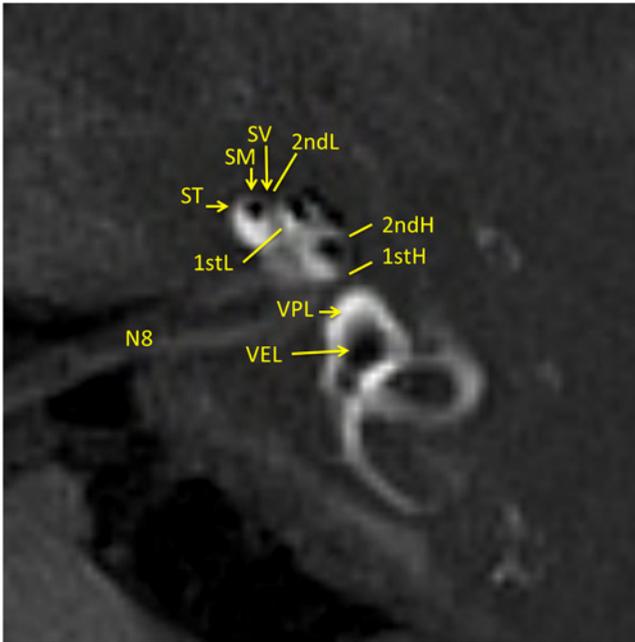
Separate visualization of endolymphatic and perilymphatic spaces and bone in human using 3D real IR TSE on 3 T MRI after intratympanic administration of Gd-DTPA. Images were obtained 24 h after transtympanic injection of 50 mM Gd-DTPA at 3T using a 32 channel head coil. N8: 8th cranial Nerve; SM: Scala Media; ST: Scala Tympani; SV: Scalavestibuli; VEL: Vestibular Endolymph; VPL: Vestibular Perilymph; 1stL: basal Lower turn; 1stH: basal Higher turn; 2ndL: Second Lower turn; 2ndH: Second Higher turn.
